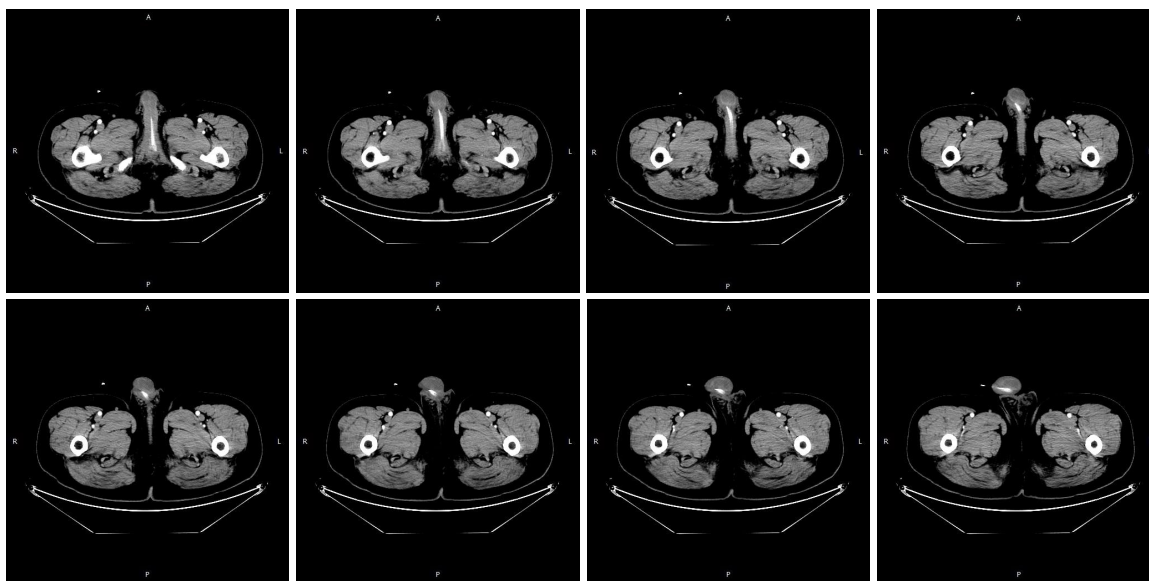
Computed tomography, penile neoplasms and anterior urethral stricture.
